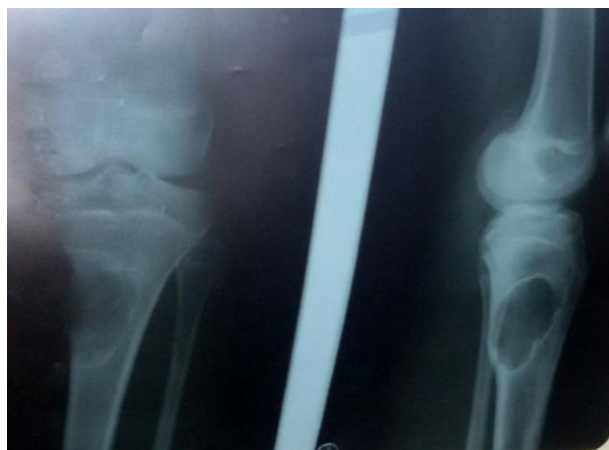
X-ray showing lytic lesion in proximal tibia
